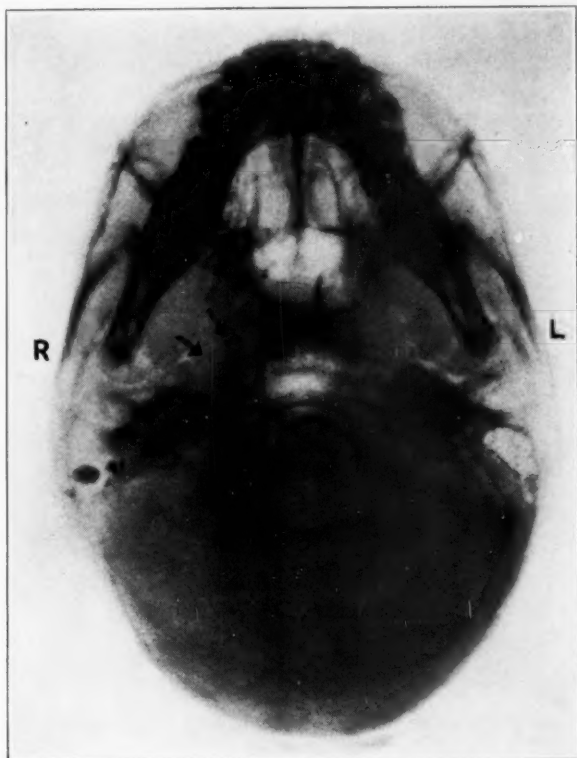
Roentgenogram of the basal view of the skull, showing a decrease in density indicating suppuration in the petrous apex on the right side, as compared with the normal appearance on the left.
